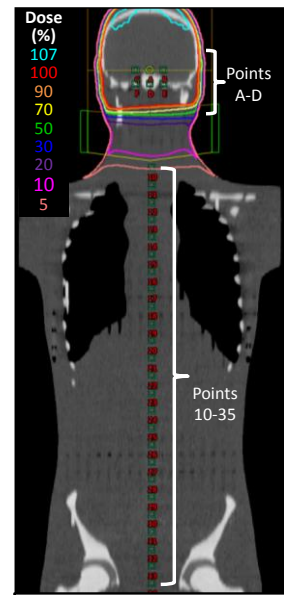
Frontal image of CT scan
